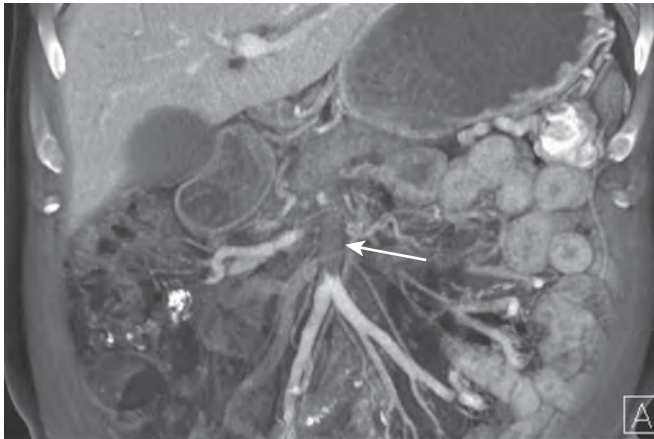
SMV thrombosis. Coronal volume-rendered contrast-enhanced CT demonstrates moderate thickening of the small bowel (predominantly in the left abdomen), with a large thrombus (arrow) in the SMV.
